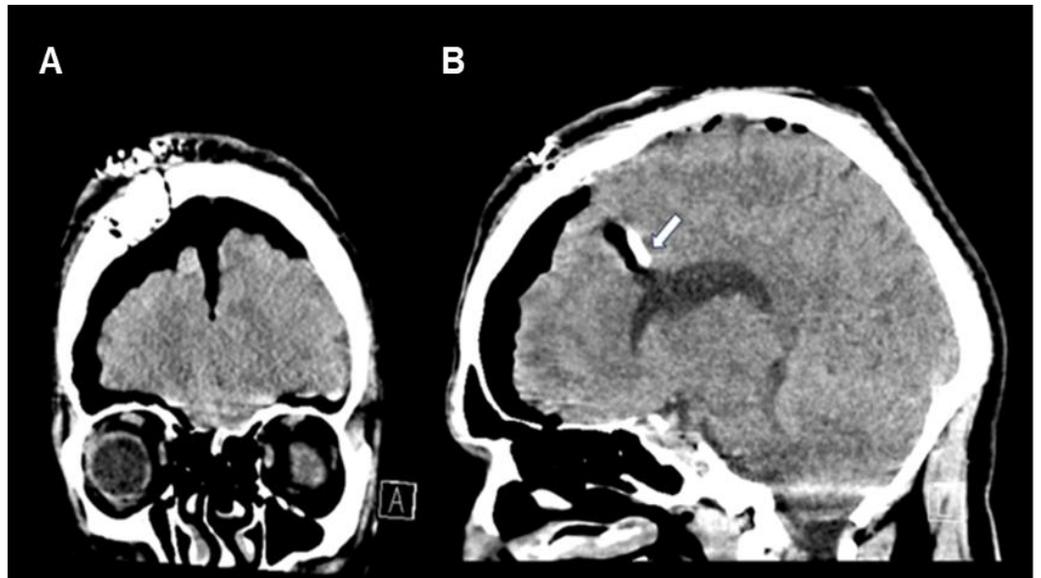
A coronal and B sagittal reformats of unenhanced CT brain showing post craniotomy changes with extensive pneumocephalus. An External Ventricular Drain is noted (arrow).
